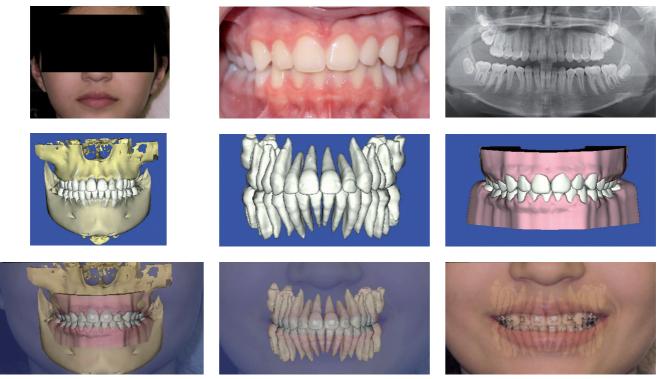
Various types of images used for care design and planning. Note: The CBCT provides information regarding bone, crown and roots. The OraScan is limited to the crowns and gingival tissue. suresmile offers the service of merging the CBCT image with the OraScan and 2D extraoral frontal images.
